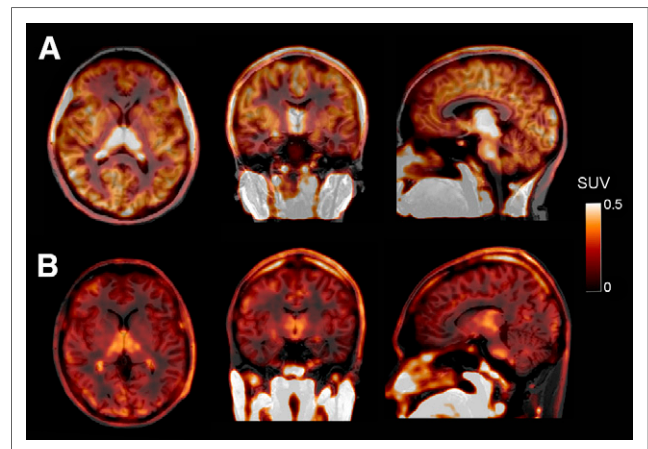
^{18}F -DPA-714 representative SUV PET images (summed from 60 to 90 min) showing axial, sagittal, and coronal views of HAB (A) and MAB (B) individual.
